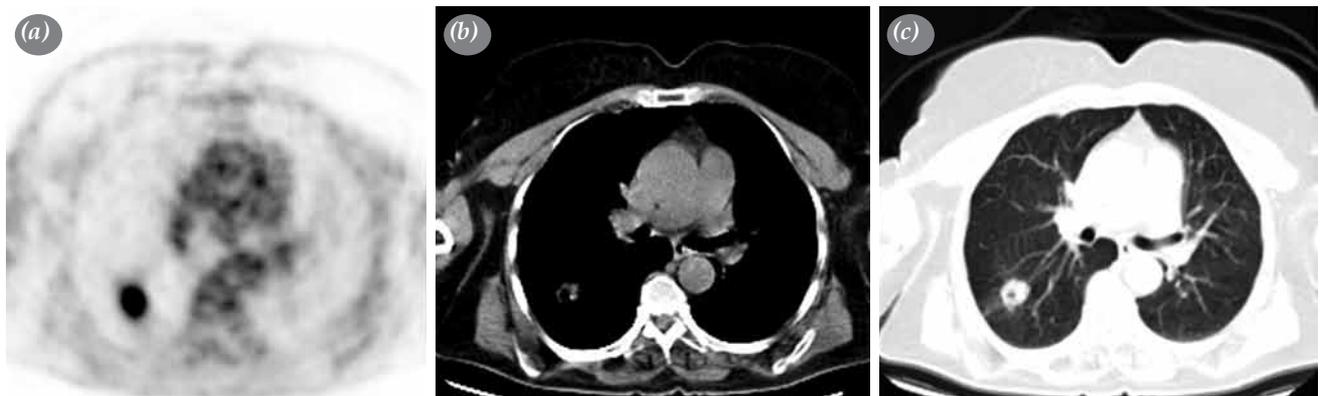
(Patient 12; 63 years old, female) Axial slice positron emission tomography (a), CT in soft tissue window (b) and in lung window (c) images showing a hypermetabolic lesion in the lower lobe of the right lung in 22 mm diameter (SUV_{max}: 5.60). After lobectomy, the diagnosis was reported as an adenocarcinoma.
